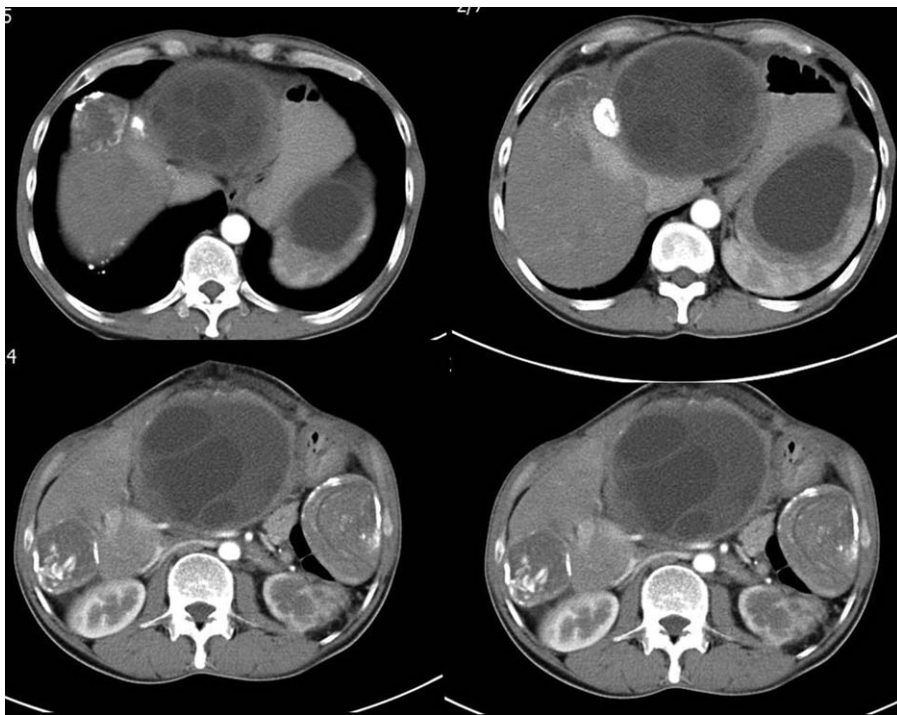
Axial abdominal computed tomography images obtained from different sections after injecting contrast material. A lesion consistent with a stage III hydatid cyst is seen in the posterior segment of the right liver lobe and another lesion consistent with a stage V hydatid cyst is seen in the anterior segment of the right liver lobe. Lesions consistent with stage I and stage V hydatid cysts are seen in the upper and lower poles of the spleen, respectively.
